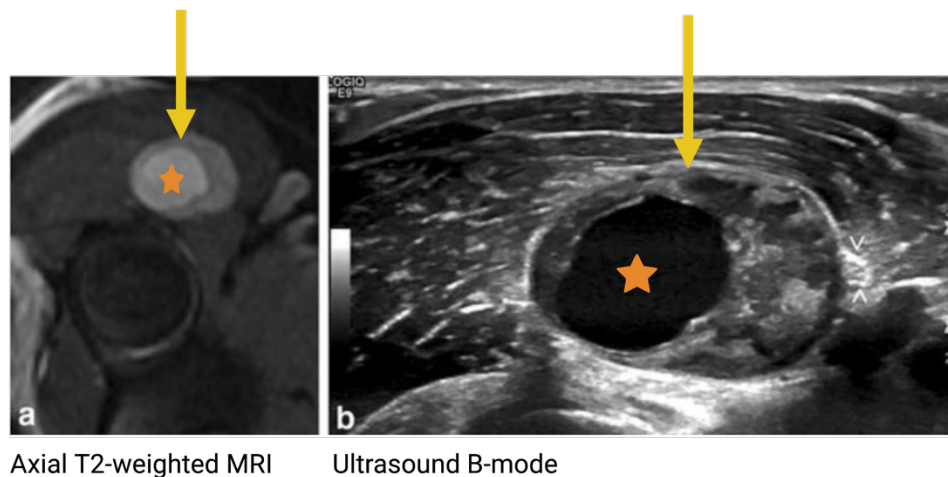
Cystic radial nerve Schwannoma imaging. (modified from Battaglia et al. (Battaglia et al., 2017)) Visual representation of radial nerve Schwannoma (yellow arrows. The prominent internal cyst (orange star) that is hyperintense with T2-weighting and hypoechoic ultrasound. No SWE maps were provided in the study.
